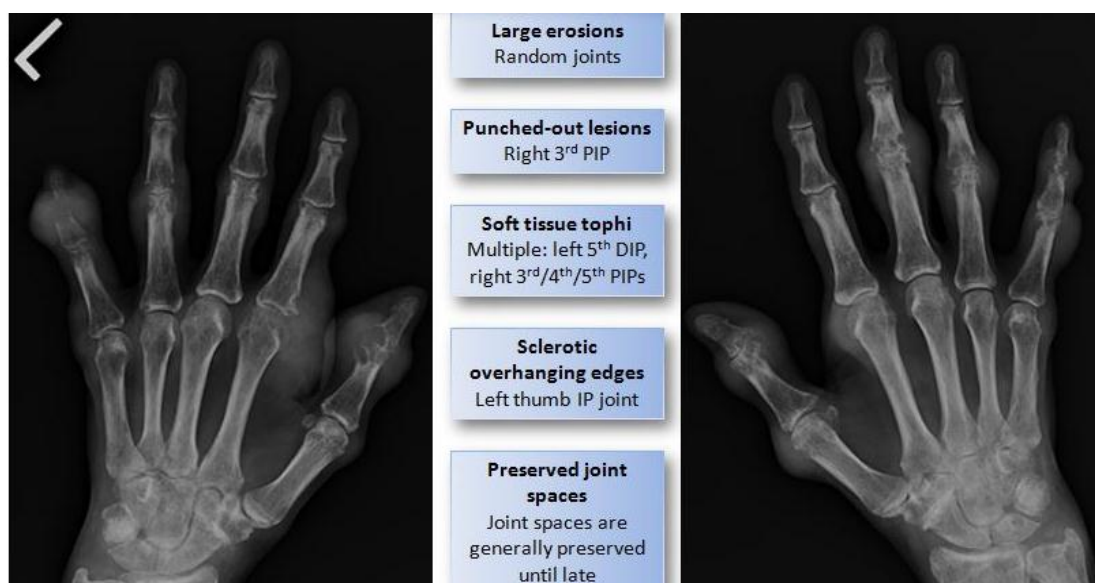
Radiographic findings in Gout
